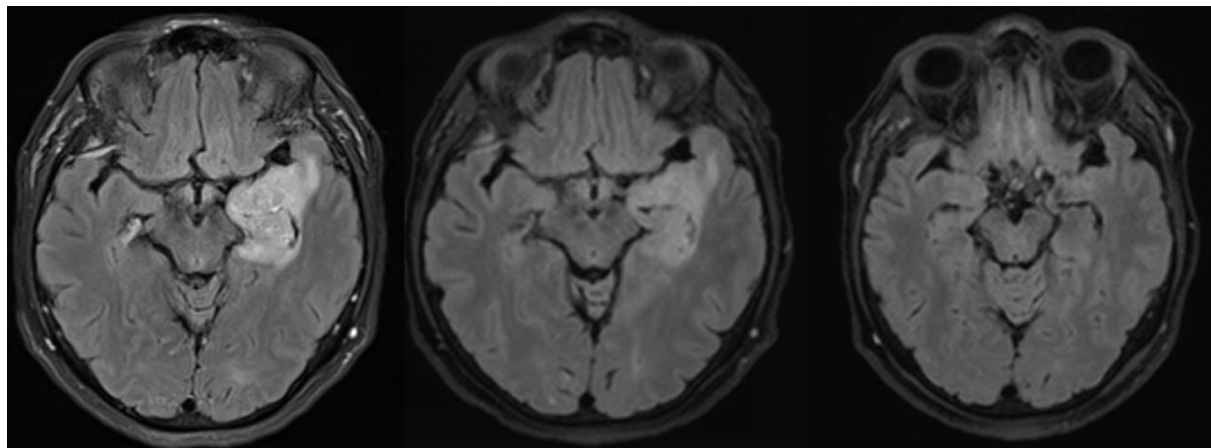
FLAIR sequence evolution: at diagnosis (left), one week post-endovascular treatment (center), and six weeks post-treatment (right).
